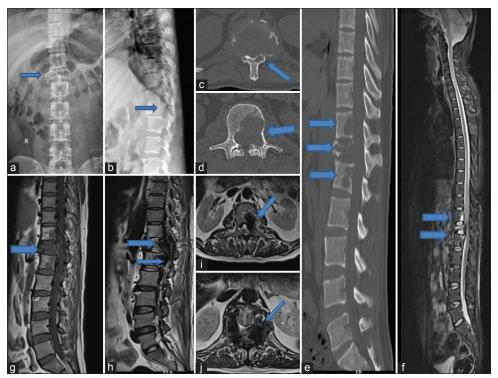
Preoperative radiographs (a and b) and CT (c-e) scan showing destruction of T12 and L1 vertebral bodies with complete collapse of T12 and partial collapse of L1 body. Preoperative MRI showing signal intensity changes in T11, T12, and L1 vertebrae with hyperintense signal on T2 imaging (f-j) and hypointense signal on T1 imaging (g). Blue arrows depict the pathology.
